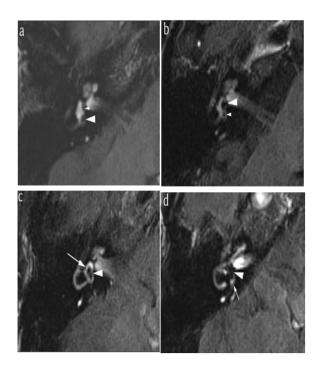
Cropped axial 3D FLAIR image of the right ear, four hours after intravenous administration of a double dose of Gd, at the level of the lower part of the vestibule. (a) The saccule (little arrowhead) and utricle (big arrowhead) may be easily distinguished. No evidence of vestibular hydrops is present. (b) In this instance, the saccule, which is typically the smaller of the two vestibular sacs, has
